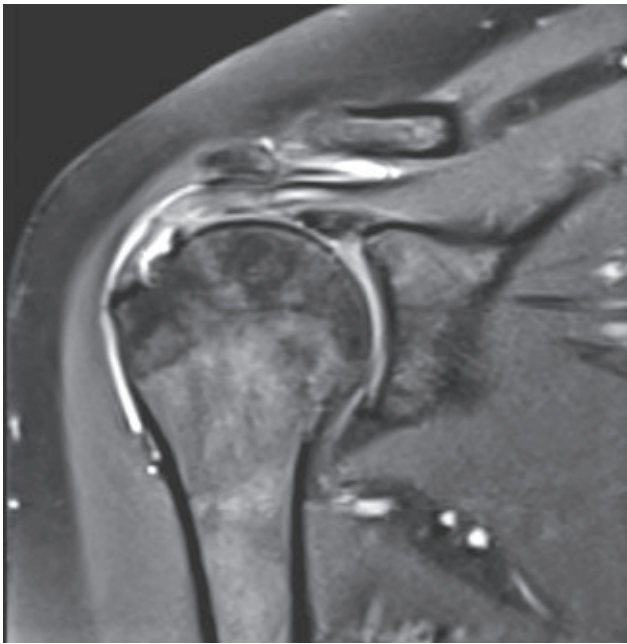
Example of an intra-tendinous tear (grade IIIC) from a T2-weighted oblique coronal section.
